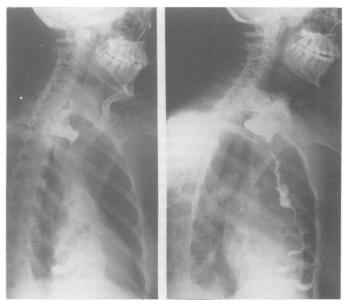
Patient 3, a 15-year-old girl with hiatus hernia, short strictured esophagus. Thal-Nissen procedure failed, recurrent stricture. Colon transplant stricture seen in radiograph.
